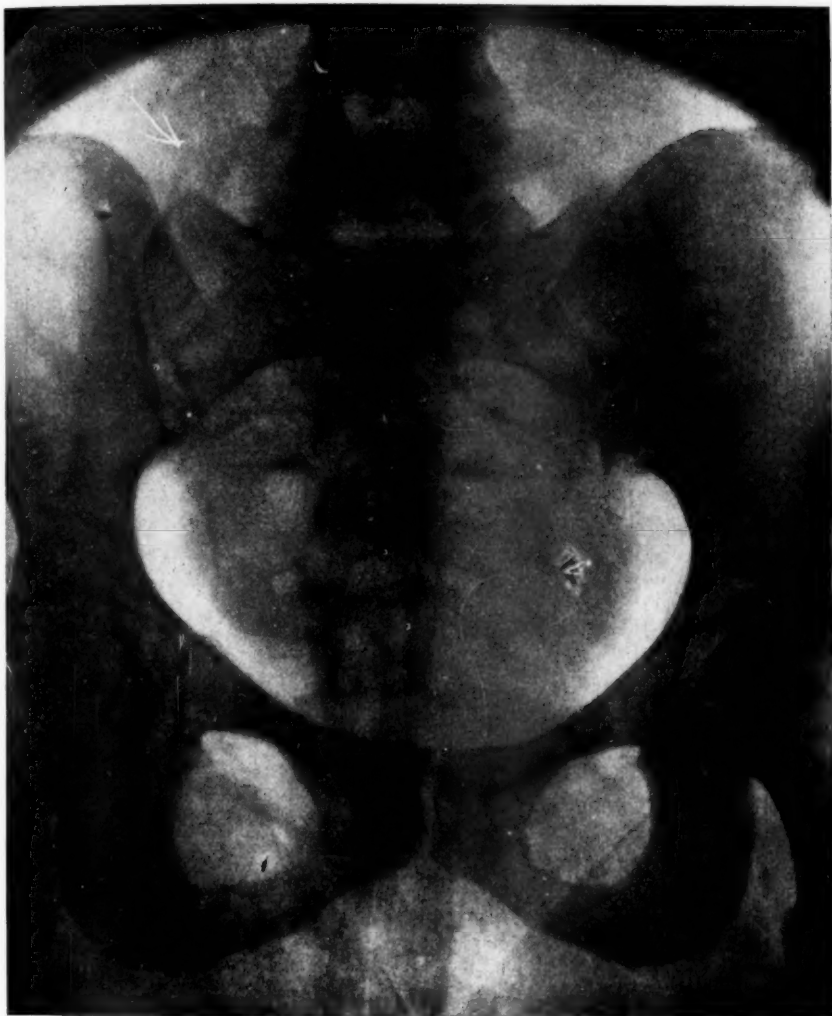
(A. P.), Mrs. P., No. 50343. Clinical diagnosis of fibroids, operation advised by surgeon. X-ray showed a complicating pregnancy about sixteen weeks duration. Delivered of normal child, 8 pounds. Aug. 20, 1928.
